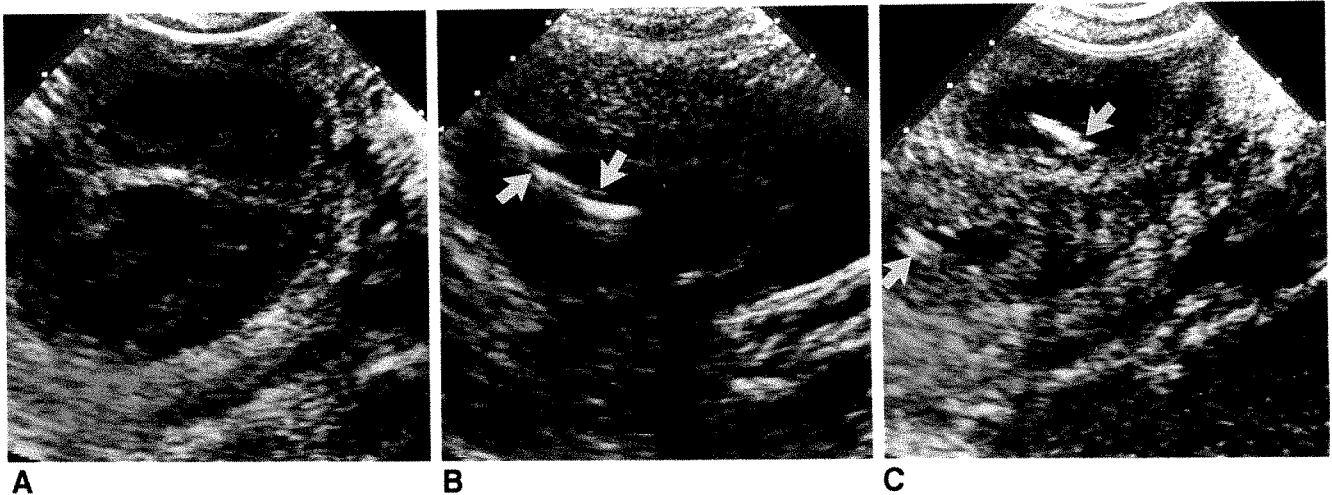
22-year-old woman who had resection of a rectal leiomyosarcoma 4 months earlier. An anastomotic stricture with abscess developed that was not amenable to CT-guided drainage because of its position behind bowel and bordered by bone.
